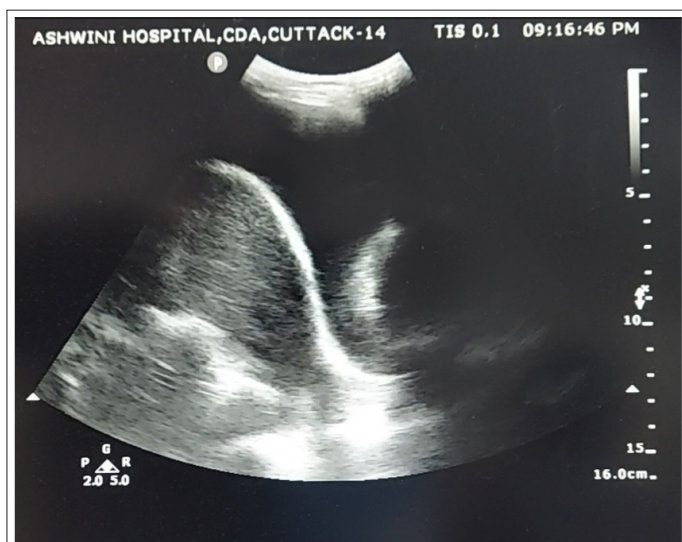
Anechoic Ultrasonography Finding
